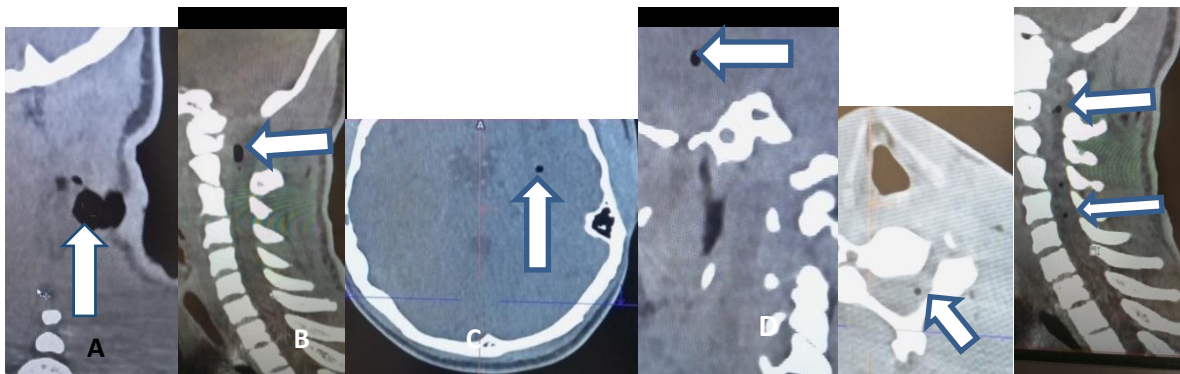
CT scan showing A subcutaneous emphysema, B intracanal spinal pneumorrhaphy, C and D pneumocephalus
